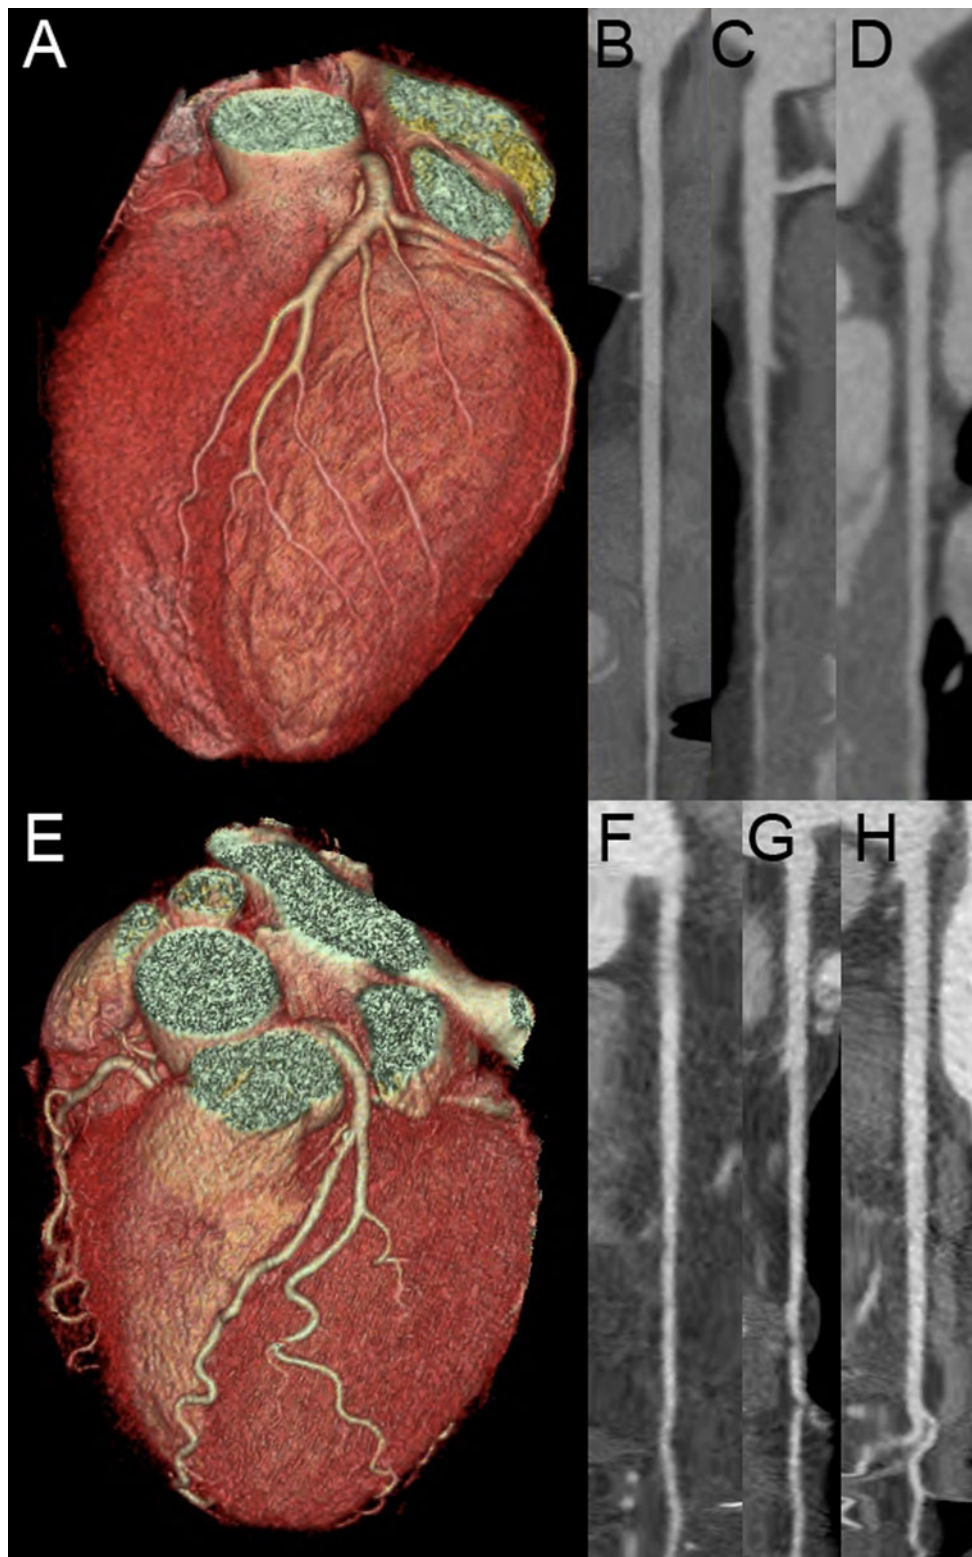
Two matched patients with comparable image quality (image quality scores 1 or 2 in all coronary segments). *Top line* volume rendered standard-definition CT image of the heart (a) and multi planar reconstructions of the right coronary artery (b), the left anterior descending artery (c) and the circumflex artery (d). Heart rate was 58 bpm, heart rate variability of 1.2 bpm and a body mass index
